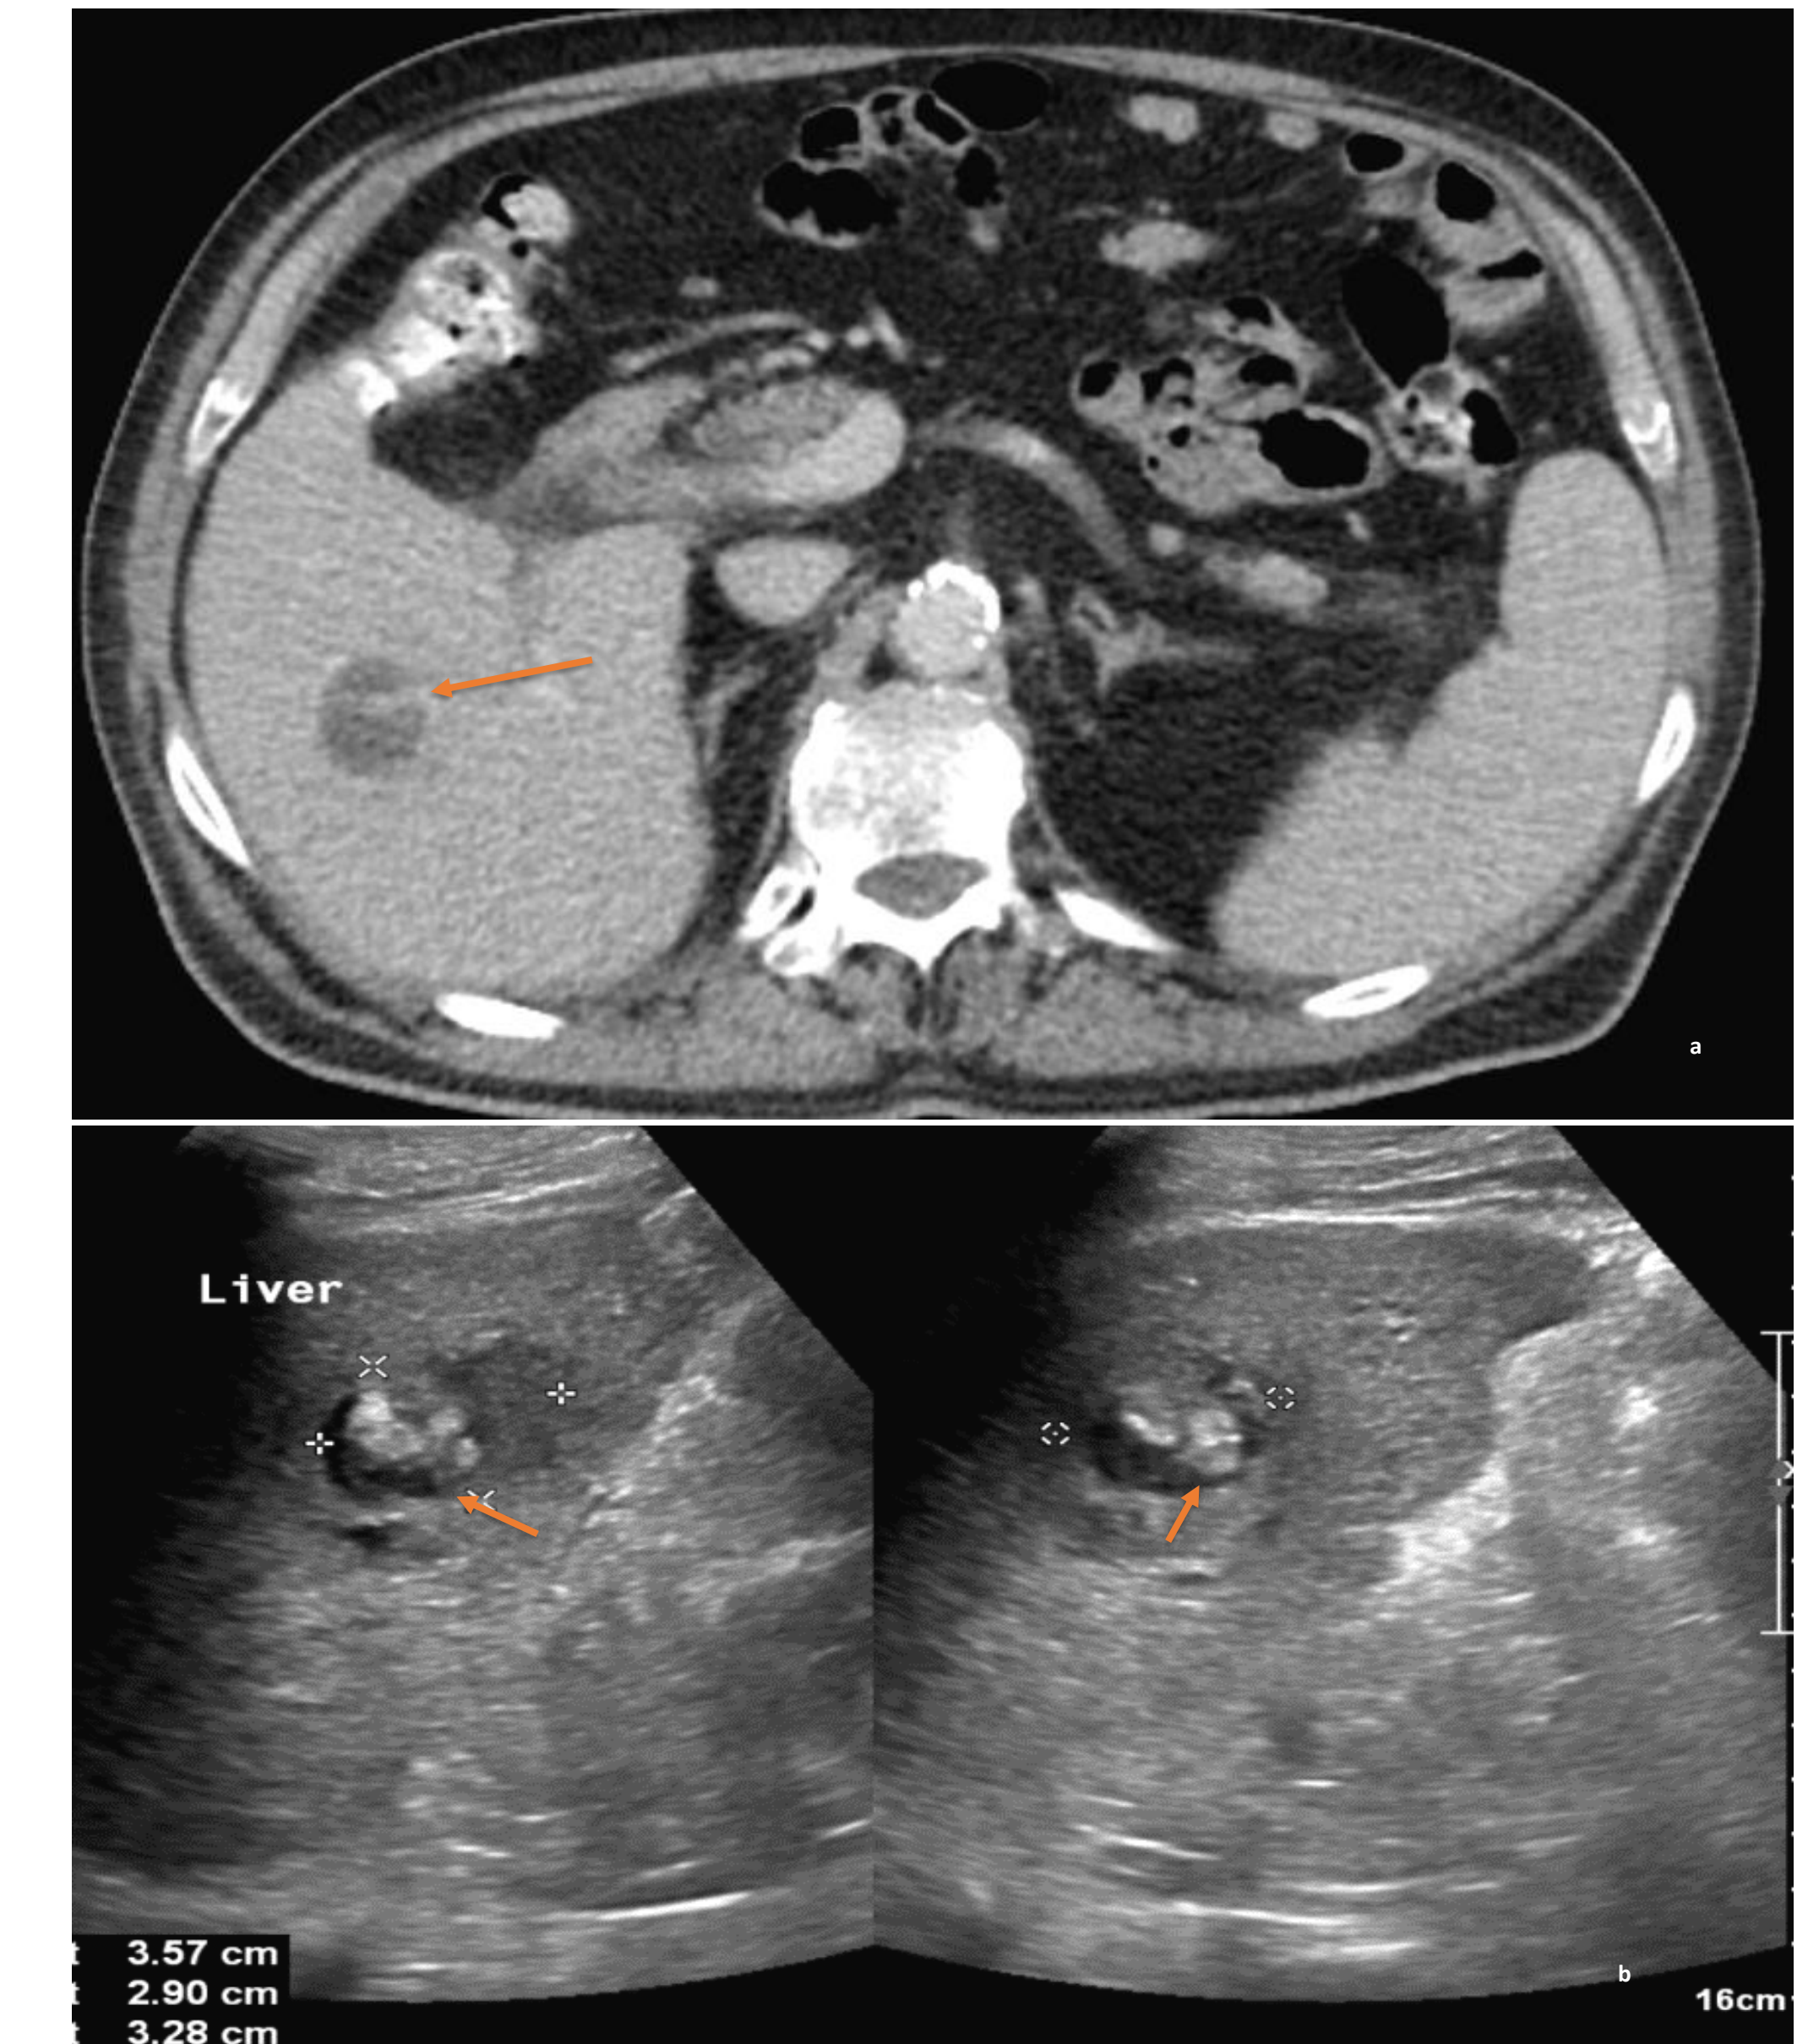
Triple phase CT scan of the abdomen and pelvis in the transverse plane (a) demonstrating a 2.8 cm mass (arrow) in the right lobe of the liver with a small area of linear enhancement. Abdominal ultrasound demonstrating an area of mixed echogenicity (arrows) with areas of increased and decreased sonographic texture measuring 3.6 x 2.9 x 3.3 cm in segment 8 of the liver (b)
